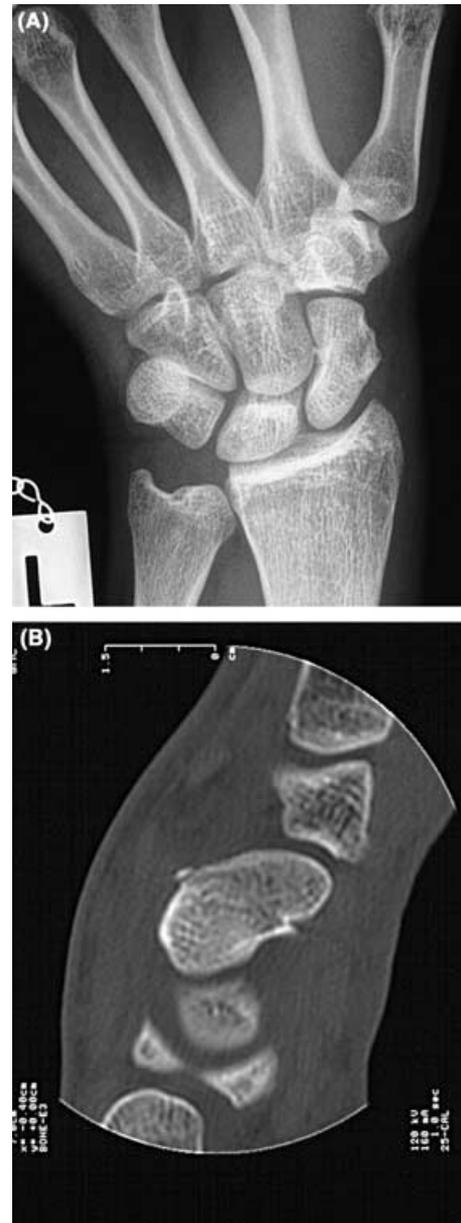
(A) Initial radiograph (posteroanterior in ulnar deviation) demonstrating slight deformity at the ulnar cortex, consistent with recent trauma, although the fracture itself cannot be seen. (B) A CT scan is used to confirm the diagnosis; the fracture line is now clear and can be seen to involve both cortices, with the potential for displacement.
